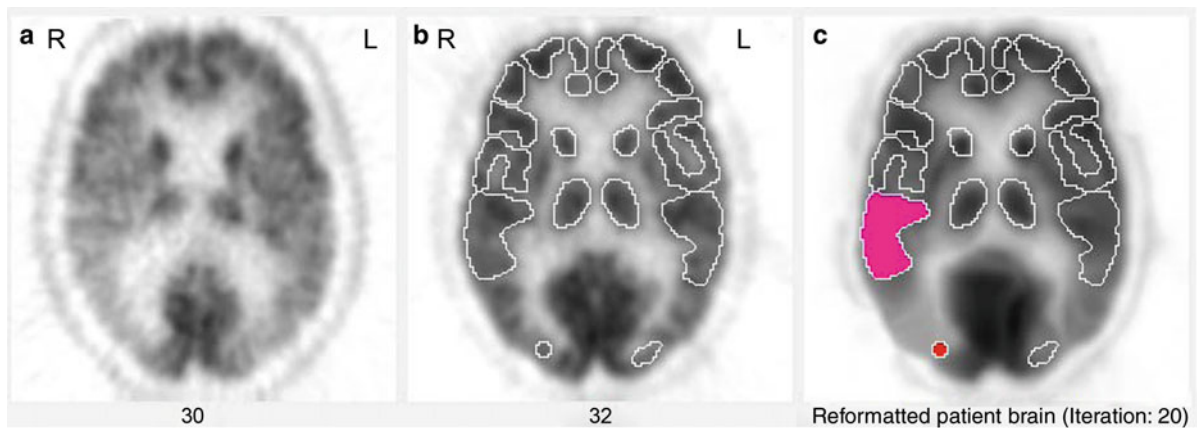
An example of a model-based approach for defining ROIs on a PET FDG image of the brain. (a) One slice of a patient's FDG brain image. (b) One slice of the "standard," or model, normal FDG image. Regions of interest have already
